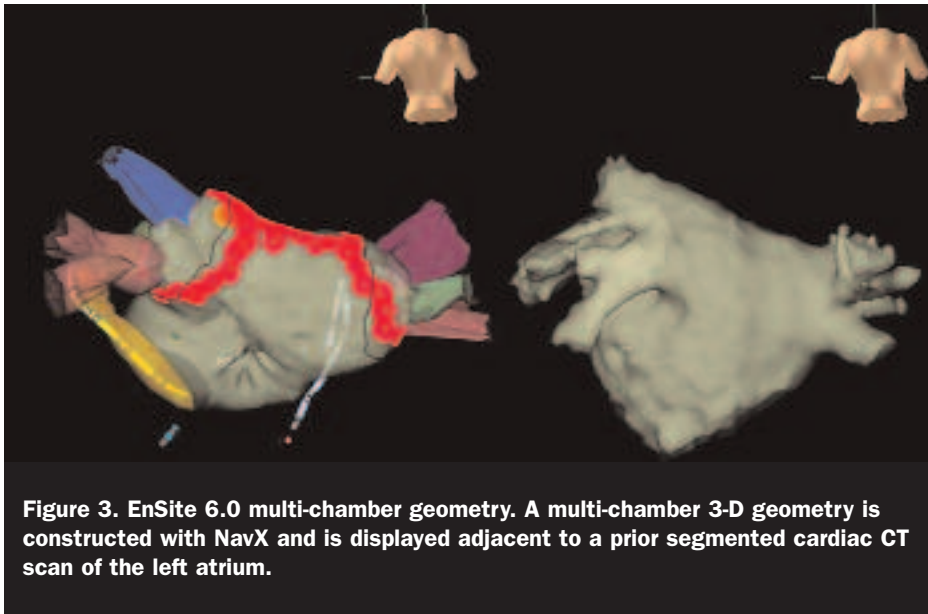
EnSite 6.0 multi-chamber geometry. A multi-chamber 3-D geometry is constructed with NavX and is displayed adjacent to a prior segmented cardiac CT scan of the left atrium.
